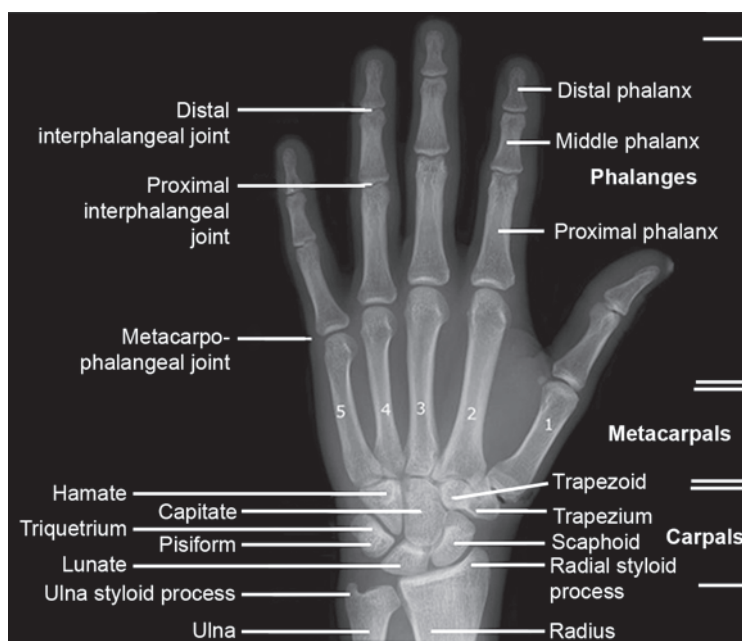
X-ray showing skeletal landmarks around hand
